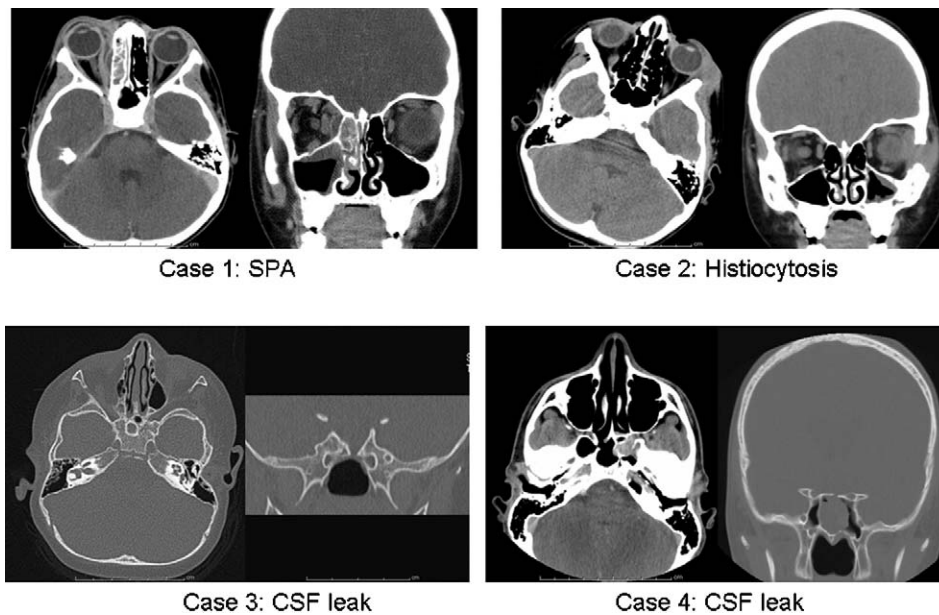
Selected cases with infectious, neoplastic, congenital and traumatic etiologies. Computed tomography images are shown in the axial and coronal planes for four cases treated with image-guided endoscopic sinus and skull base surgery. Case 1 shows a subperiosteal abscess (SPA) adjacent to opacified left ethmoid air cells. Case 2 depicts Langerhans cell histiocytosis of the left orbit. Cerebrospinal fluid leaks requiring surgical repair of the skull base are shown in Case 3 (congenital) and Case 4 (traumatic).
